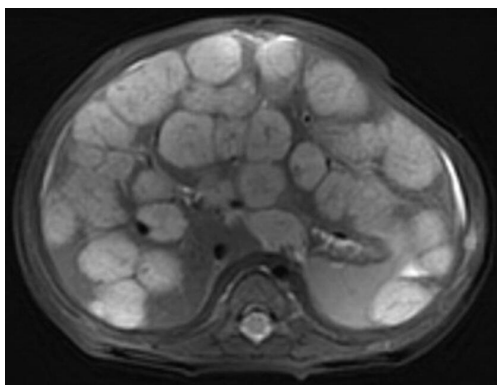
Before treatment T2-weighted axial MR image shows multiple hyperintense nodular lesions in the liver.
